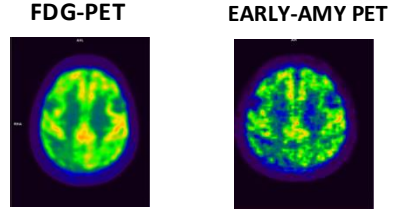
axial PET images with FDG and Florbetapir in the same patient
